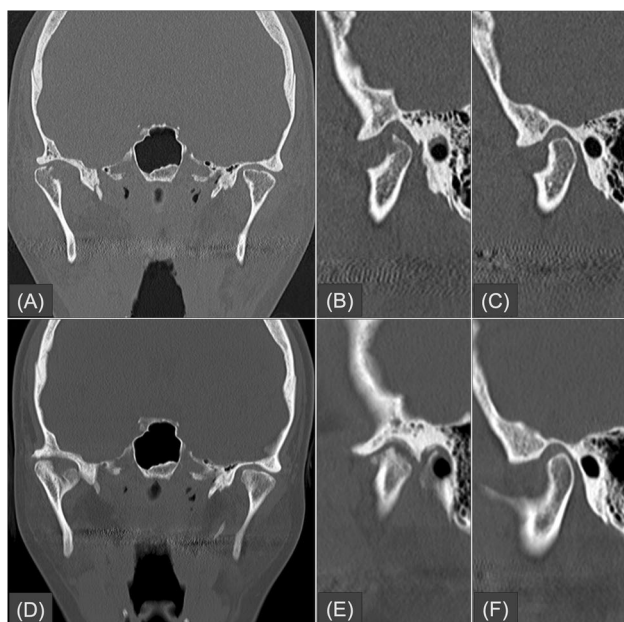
Initial CT scans in coronal (A) and sagittal (B) planes of a 49-year-old woman revealed a right mandibular condylar head fracture with fracture site displacement and right temporomandibular joint (TMJ) subluxation. No apparent fracture in the left mandibular condyle is shown in (C). Coronal (D) and sagittal (E) reformatted images of the follow-up CT scan, taken 10 months after conservative treatment, showed condylar deformity, marked osteophyte formation, and potential remodeling. In contrast, no degenerative changes were observed in the left TMJ on the follow-up CT (F)
